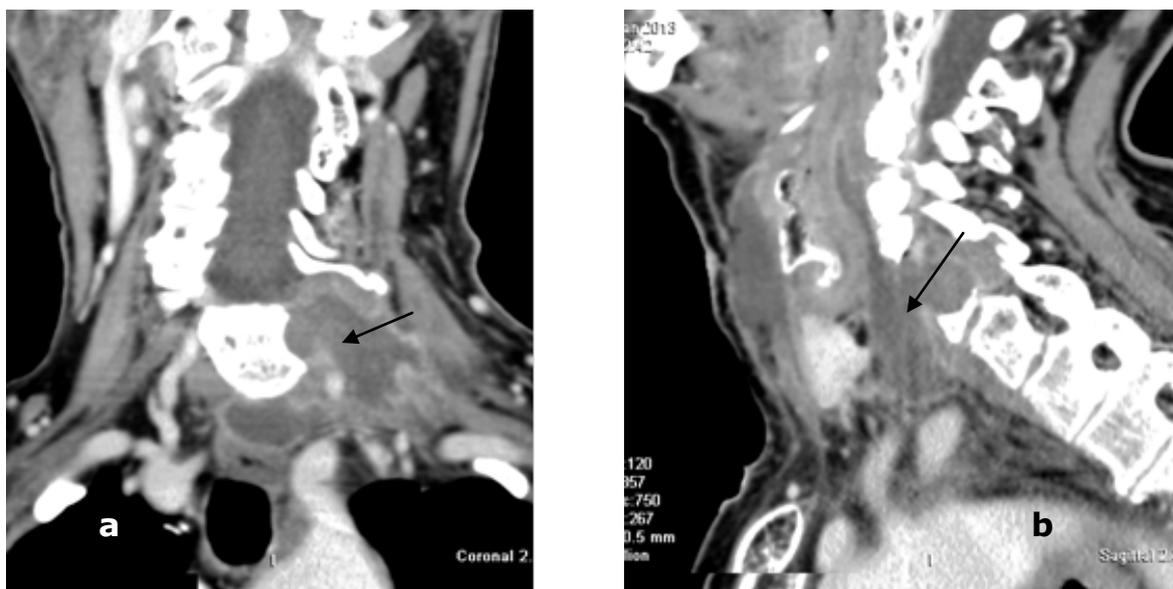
Coronal(a) and sigittal (b) CT views, in the left paravertebral space an irregular liquid accumulation with an edge postcontrast density increase can be observed,the condition after a vertebrae operation
